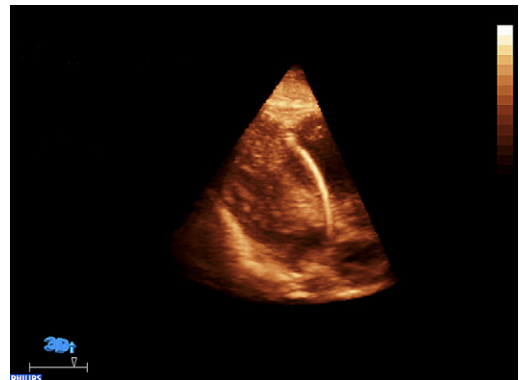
Real-time 3D echocardiography shows the tip of the biopptome as it pulls away a piece of endocardium resulting in actual eversion of the right ventricular apex (in fact apical free wall, in fact a dangerous area for biopsy because of risk of rupture, nicely demonstrated by RT3D). (See video. Access video in the online version of this article at: <http://www.cardiology.theclinics.com>.) The still image shows the biopptome everting the right ventricular apex moments before extracting some myocardial tissue. (Courtesy of L. Ward, RCS, RVT, Bothell, WA, and G. Shirali, MD, Charleston, SC.)
